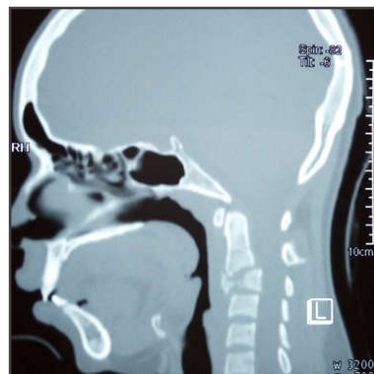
Tear drop fracture of C3 sagittal reconstruction CT scan
